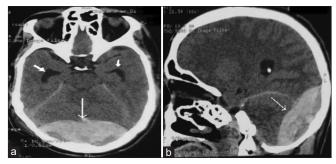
(a) Preoperative axial computed tomography (CT) scan head after 24 h of admission showing an increase in the size of hematoma (thin arrow) with an increase in the size of temporal horns (thick arrow) (b) preoperative sagittal CT scan head after 24 h of admission showing an increase in the size of hematoma (thin arrow).
